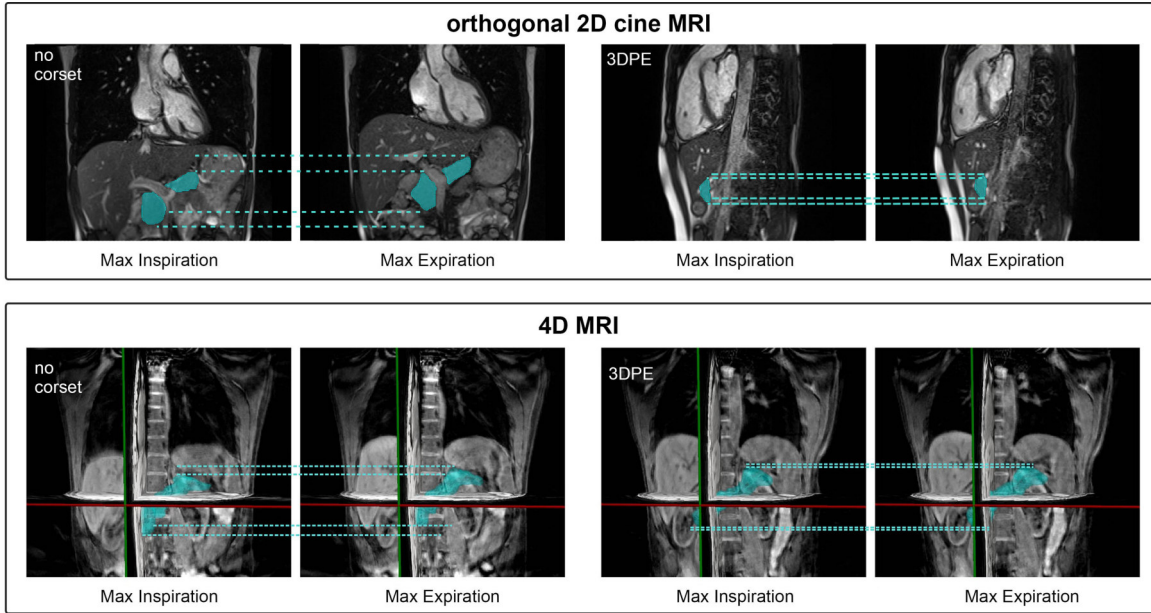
Orthogonal single-slice 2D cine (coronal and sagittal) (*top*) and 4D MRI (*bottom*) of healthy volunteer in free breathing (*left*) and wearing the 3DPE corset (*right*) showing the state of maximum expiration and inspiration. The pancreas is segmented and lines are added at the caudal and cranial edge of the pancreas to visualize the amount of pancreatic motion.
